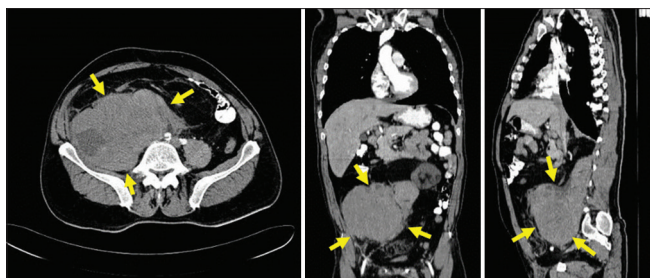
Abdominal computed tomography (axial, coronal and sagittal views) shows a large, lobulated mass in the right paravertebral region extending to the middle area of abdomen and pelvis
